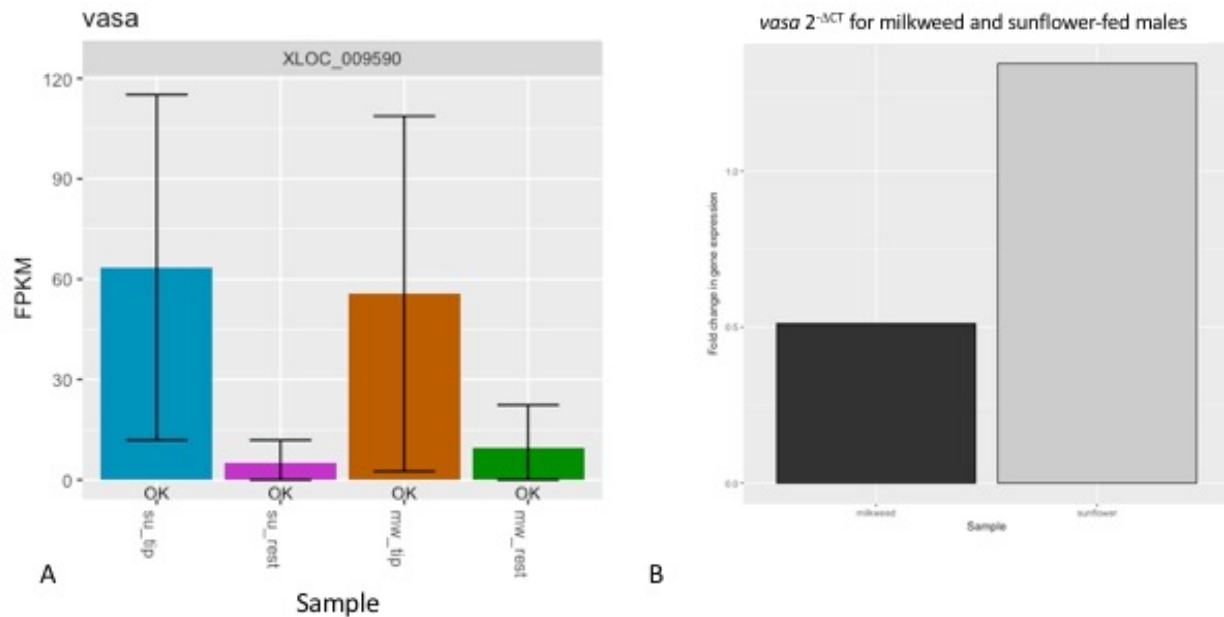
vasa* is upregulated in distal tips of testis. (A) Fragment per kilobase million (FPKM) counts for each sample and the (B) $2^{-\Delta CT}$ measurements for *vasa*. The FPKM (A) shows the relative amount of expression per sample; error bars represent the confidence interval for each sample. Overall, there are more transcripts in the distal tips of both diets as compared to the sunflower and milkweed proximal rest. There are more transcripts in sunflower-fed males as compared to milkweed-fed males, according to the $2^{-\Delta CT}$ data (B), however it is not a large difference.
